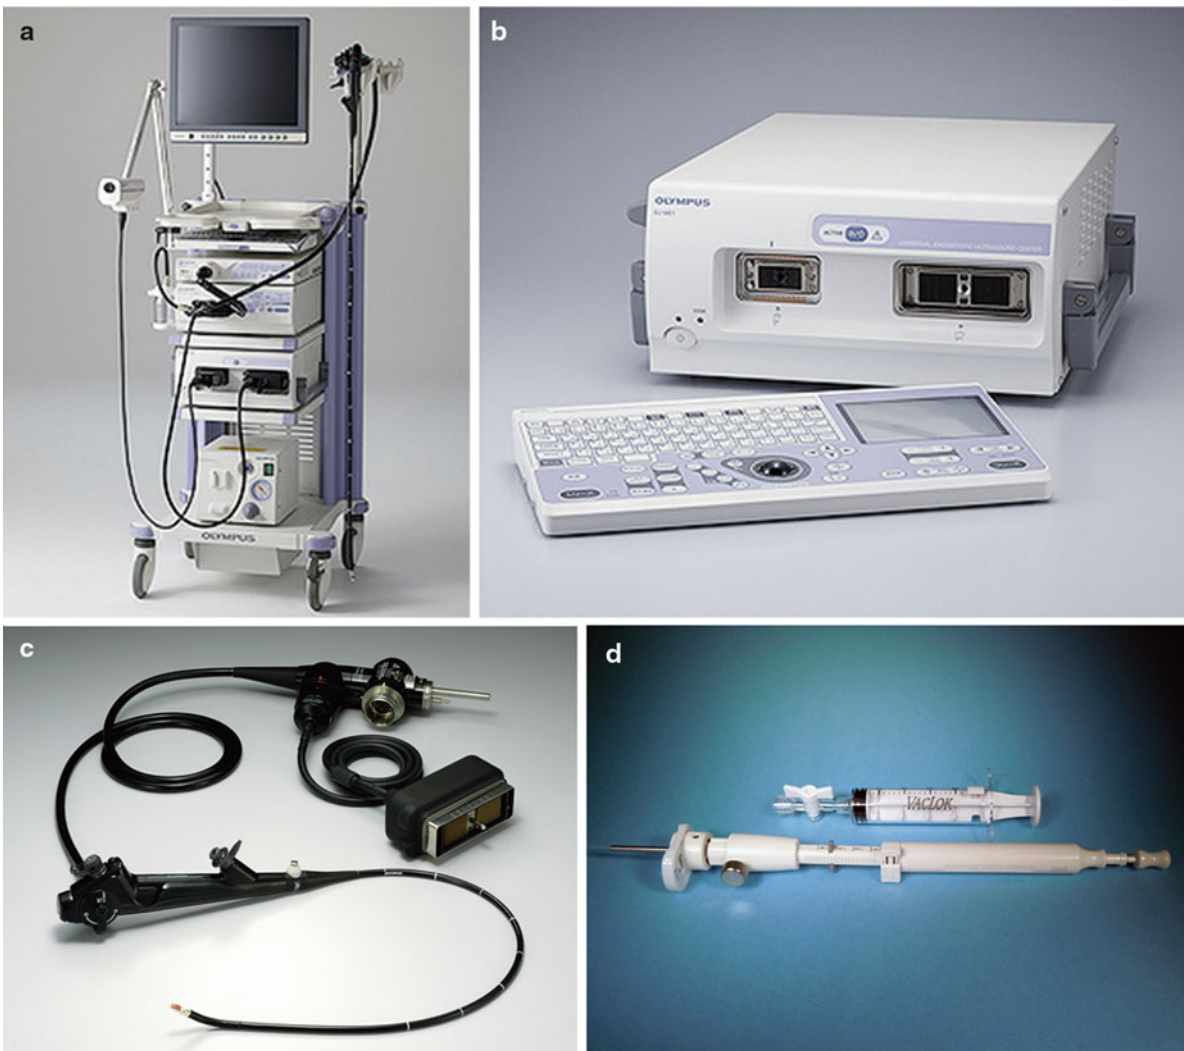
The endobronchial ultrasound system. The tower includes the universal endoscopic ultrasound scanner with capabilities of radial probe EBUS imaging as well as the convex probe endobronchial ultrasound (EU-ME1, Olympus, Tokyo, Japan) (a, b). The convex probe
